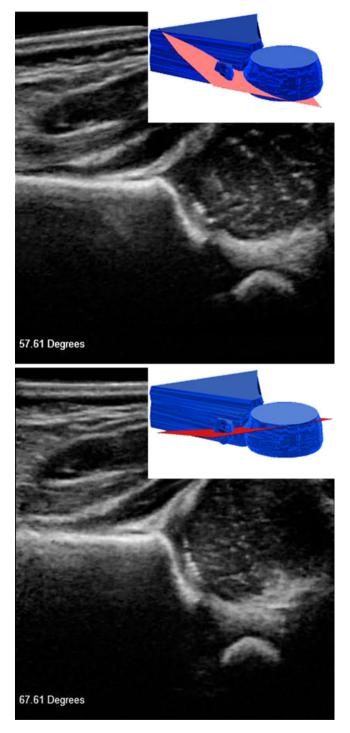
Two extracted 2D images from a single 3D ultrasound scan of an infant hip, taken at the orientations shown on the models at the top right of each frame, representing two different probe positions in axis 1 (antero-posterior). Note the typical 10° difference in the measured alpha angles between images. Paper #: PA-138
